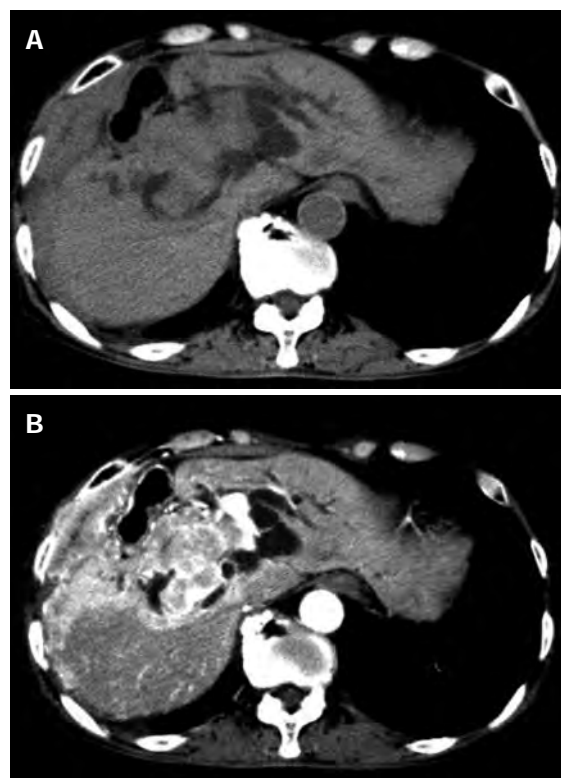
Computed tomography showing dilatation of the intrahepatic bile ducts and a heterogeneous large mass 15 cm in diameter located in the right hepatic lobe. A: Plain computed tomography (CT); B: Contrast-enhanced CT.
